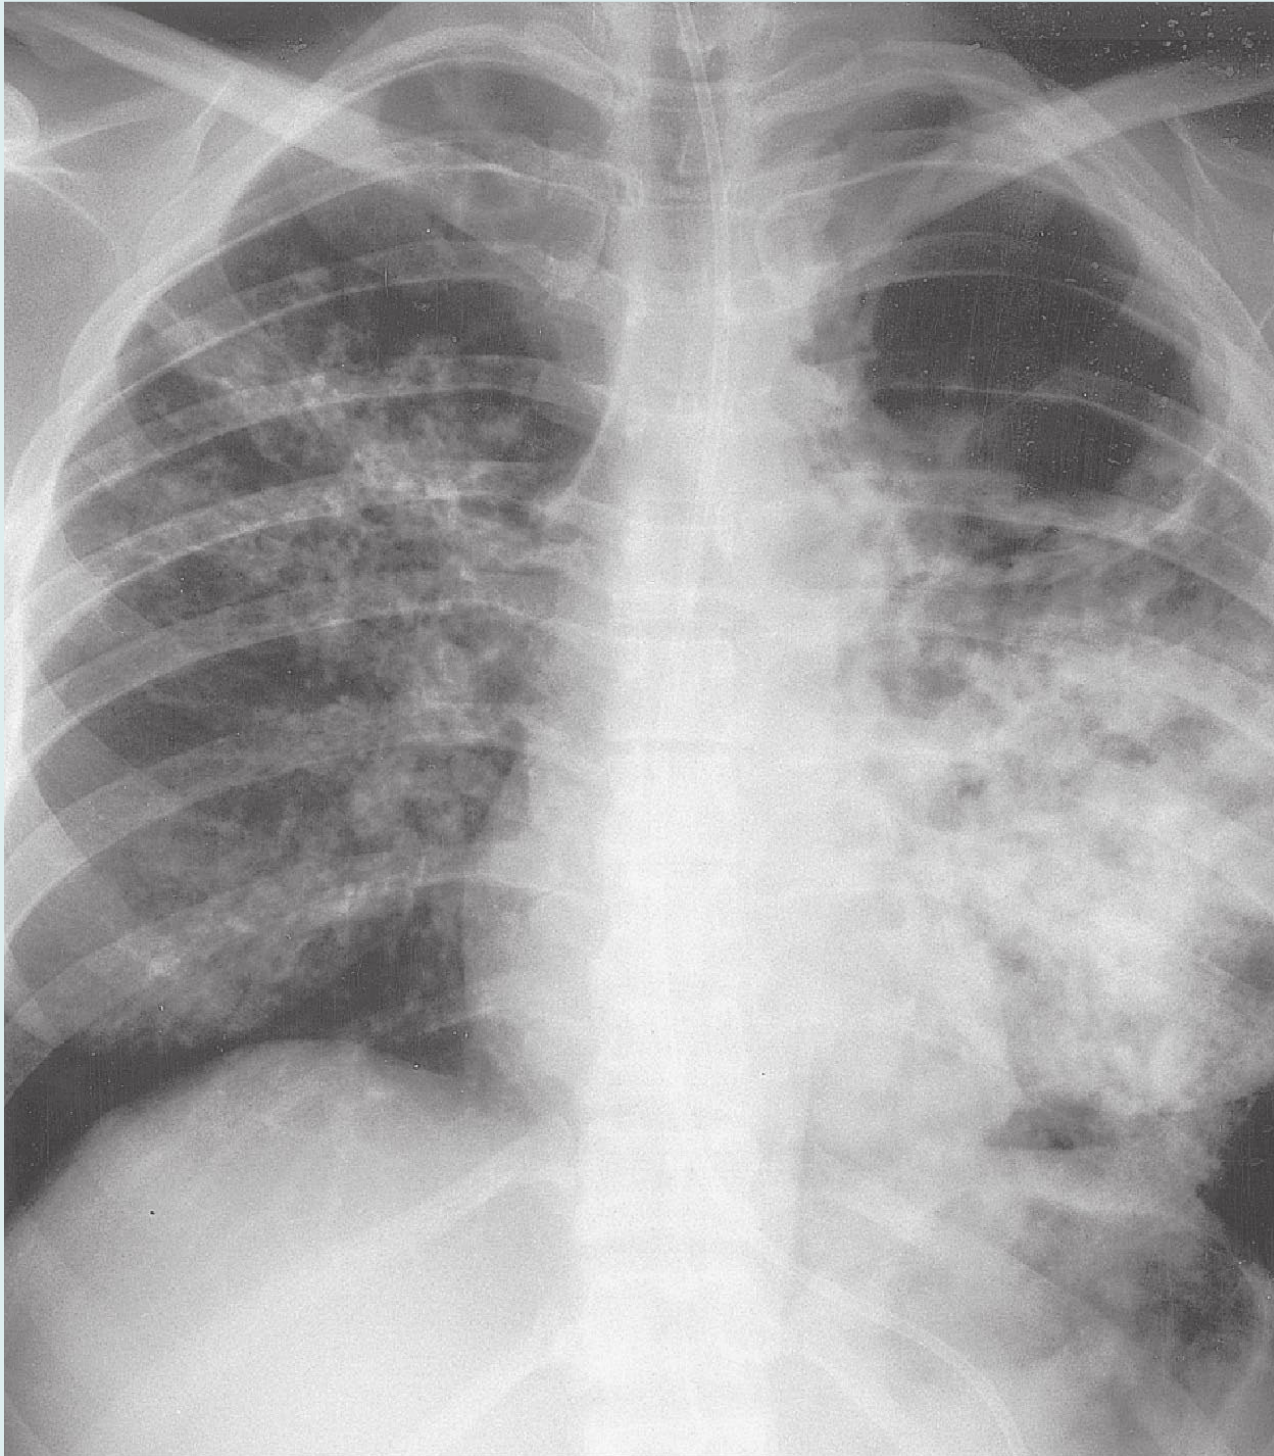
Chest x-ray. (Reproduced, with permission, from Fishman AP. Fishman's Pulmonary Diseases and Disorders, 3rd ed. New York: McGraw-Hill, 1998:2487.)
